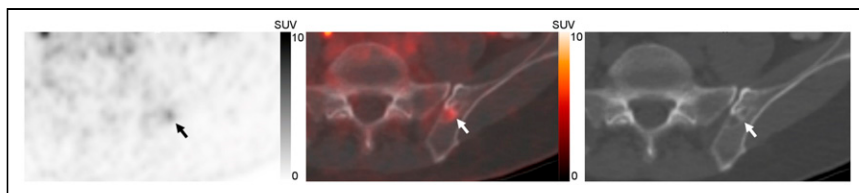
A 60-y-old patient with BCR PCA and PSA of 3.9 ng/mL. Axial ^{18}F -DCFPyL PET (left), ^{18}F -DCFPyL PET/CT (middle), and CT (right) images show a single area of subtle PSMA-avid uptake with SUV_{max} of 3.9 in left iliac bone and mixed sclerotic and lytic CT features (arrows). This IBL was stable for 4 mo and negative on 4 other staging modalities; thus, the IBL was interpreted as benign.
